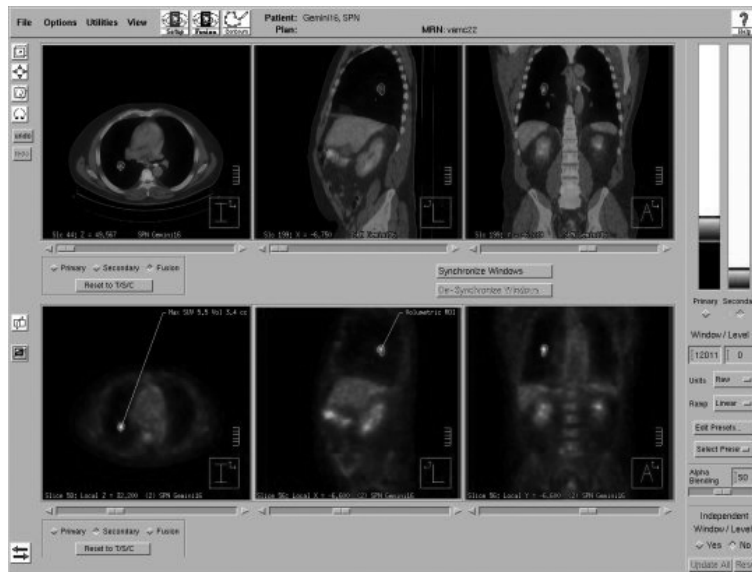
Combining CT and PET data. The CT scan (top row) provides information about the patients anatomy. PET has a higher diagnostic accuracy for staging lung tumours compared to CT, but has a much lower spatial resolution. The PET scan (bottom row) clearly reveals a lung tumour. Image courtesy [1].
